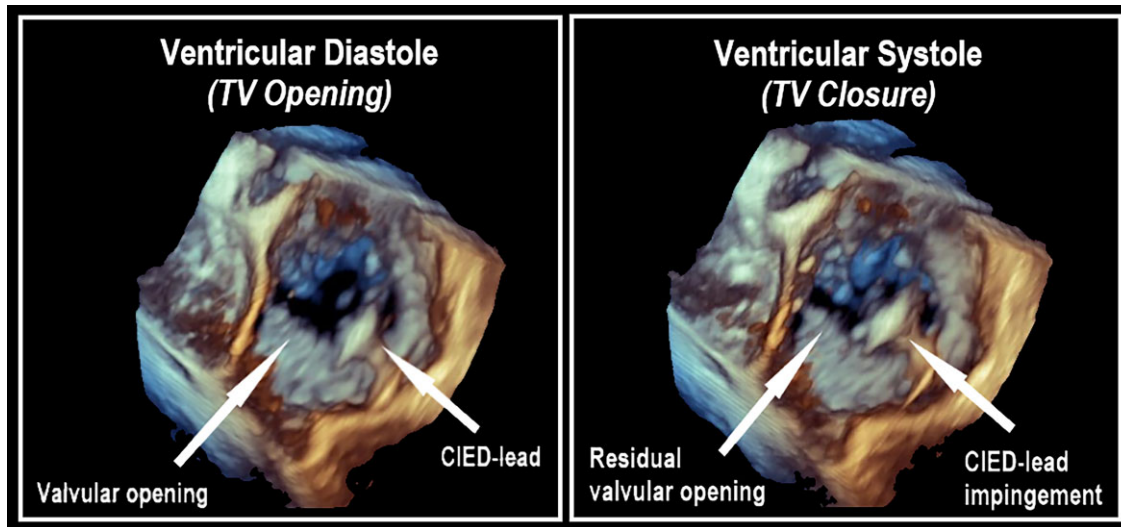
Three-dimensional transoesophageal echocardiogram showing residual valvular opening during ventricular systole due to lead impingement on tricuspid valve posterior leaflet causing inadequate leaflet coaptation.
